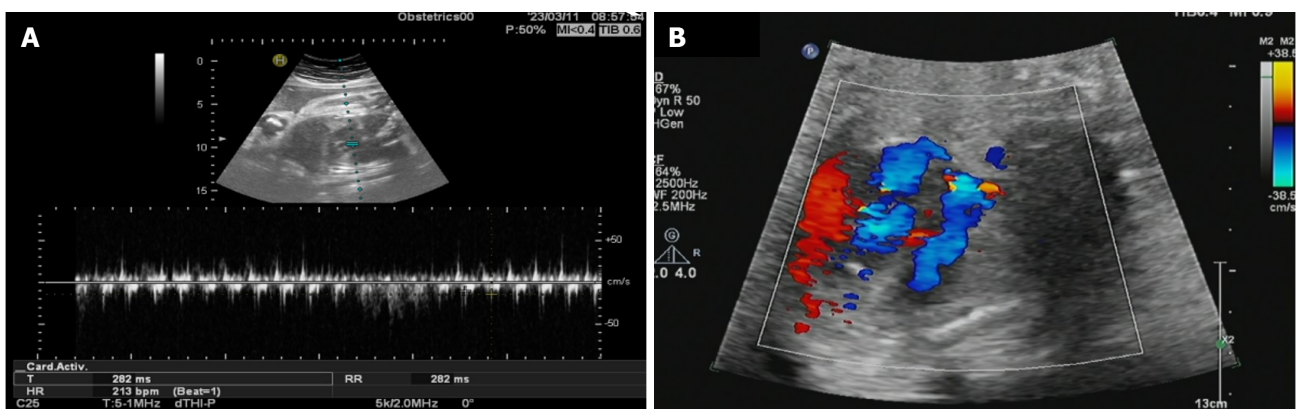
March 11, 2023, 34 + 6 B-mode ultrasonography images obstetric color ultrasound and fetal heart color ultrasound. A: B-mode ultrasonography image obstetric color ultrasound; B: Fetal heart color ultrasound.
